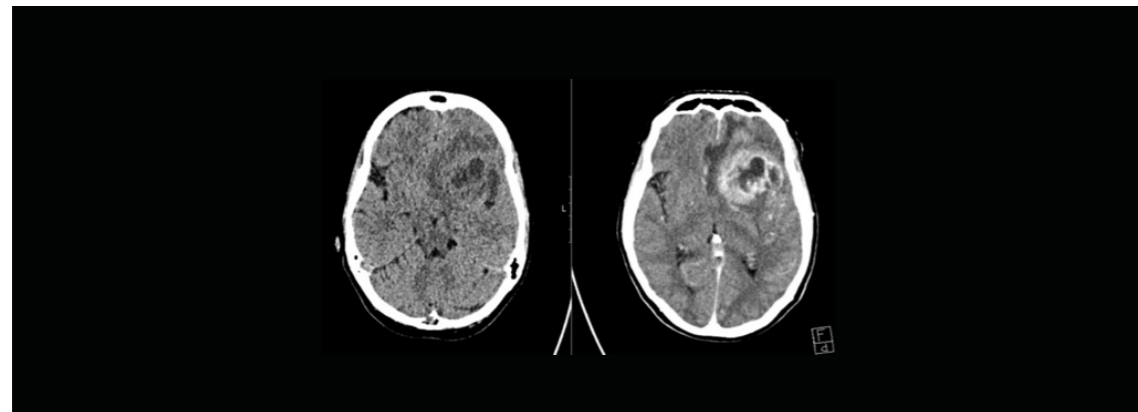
CT images of the patient at first visit, left pre-contrast, right post-contrast
